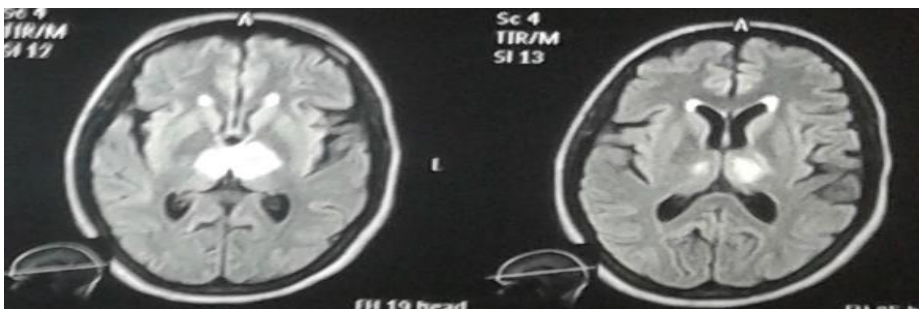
FLAIR images showing involvement of either side of mid brain and bilateral thalami
